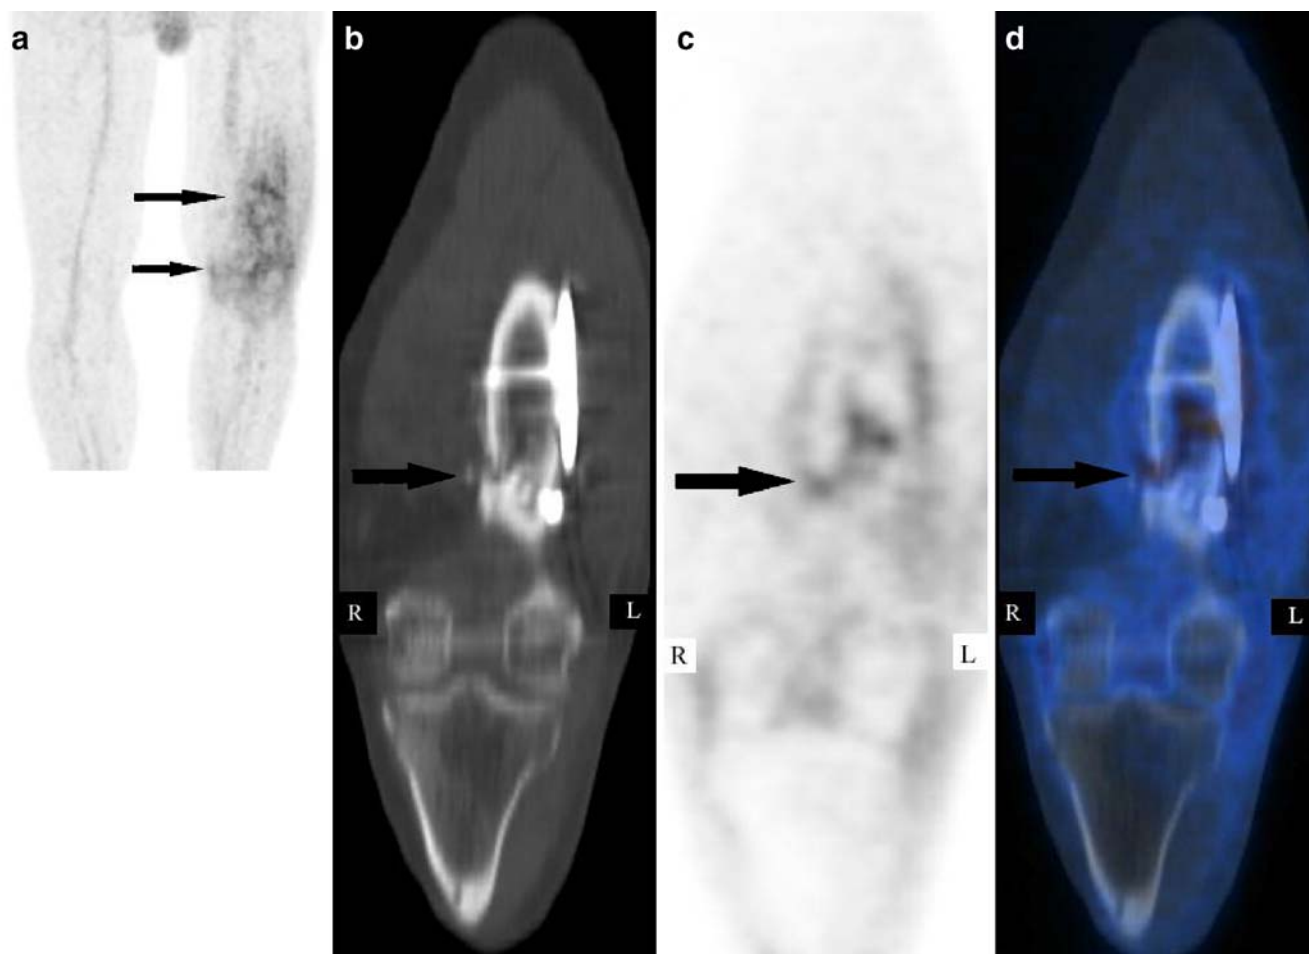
A 32-year-old male 9 months after grade 2 open intra-articular fracture of the distal femur and insertion of metallic implants. MIP PET (a) shows diffusely increased FDG uptake in the left thigh including the knee (*arrows*). Coronal CT image (b) demonstrates osteopenia of the left distal femur with distraction of femoral
